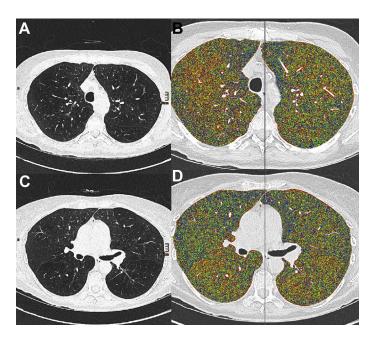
Bilateral intermediate heterogeneous emphysema. Several potential target zones become obvious by densitometry. Lateral upper lobe on the right side: (A) axial CT scan, (B) densitometry, segment 6 on the right side: (C) axial CT scan, (D) densitometry.
